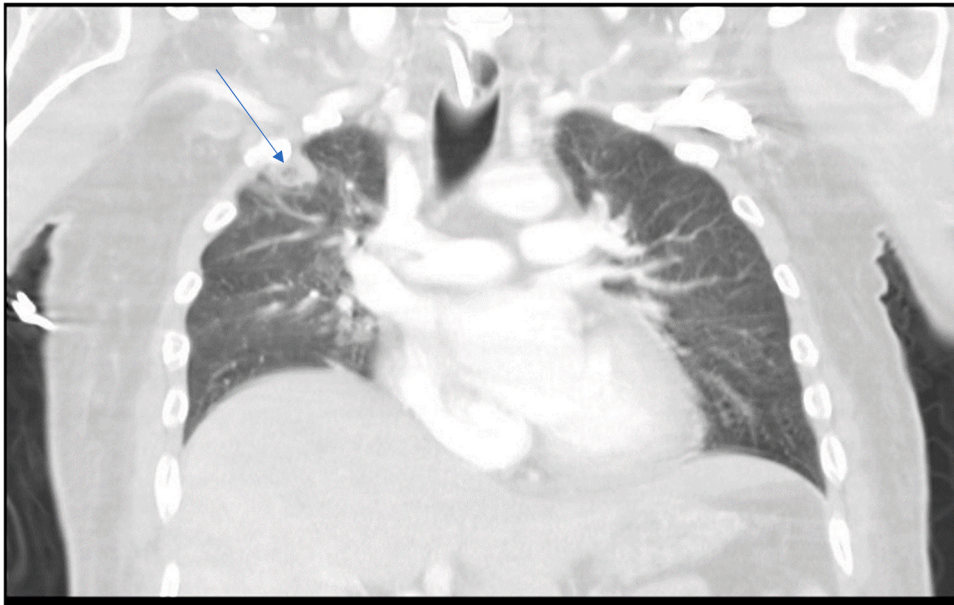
Chest CT with IV contrast showing right upper lobe lesion with central cavitation.
